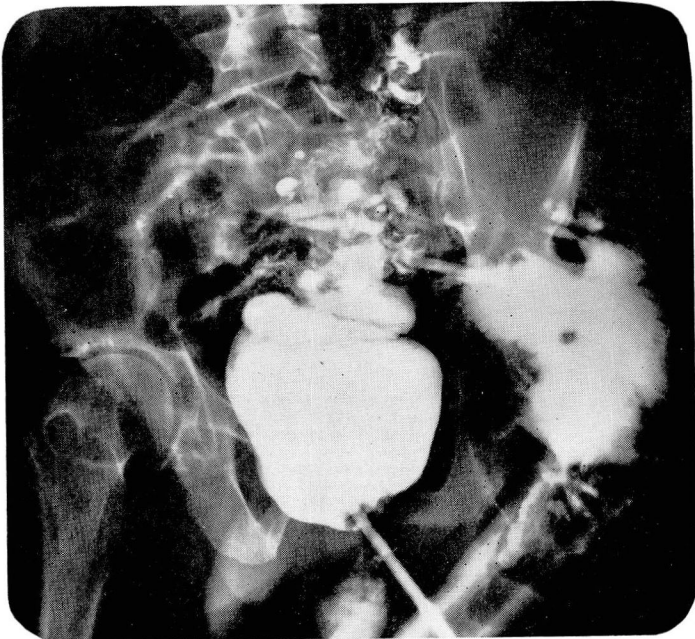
Roentgenogram of the colon after barium enema, showing diverticulosis of sigmoid colon, with diverticulitis and fistula to region of the left hip.
